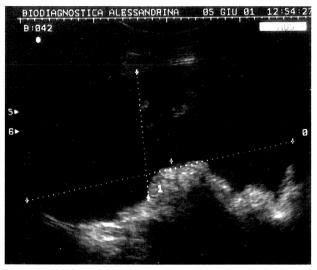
Case 2. Ultrasonographic appearance of the ovarian teratoma.
